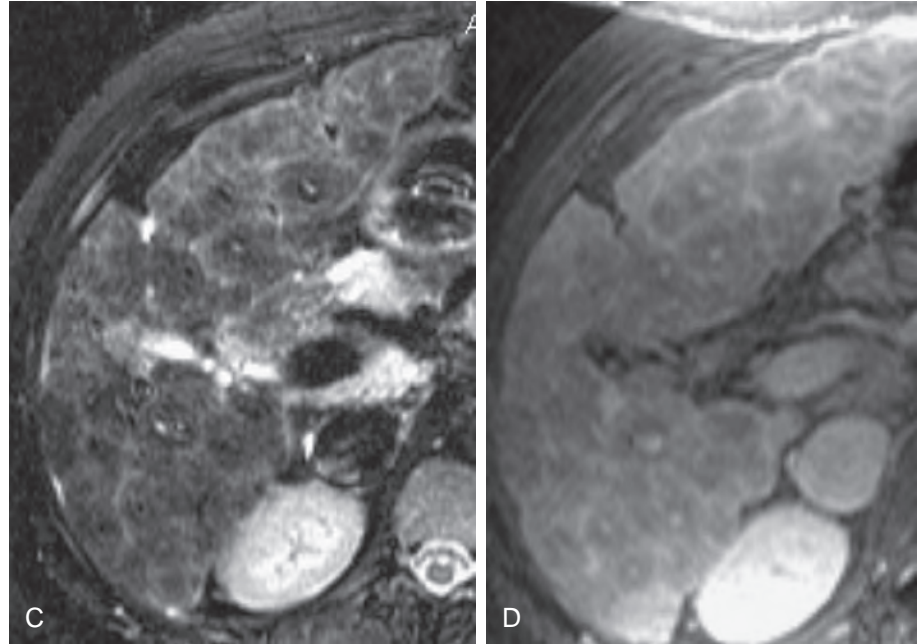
PBC: MR features. A to D. Patients with PBC may have a distinctive, conspicuous abnormality of low signal intensity centered around portal venous branches on T1- and T2-weighted MR images, the “periportal halo sign.” This abnormality consists of a rounded lesion centered on a portal venous branch, 5 mm to 1 cm in size. This pattern may involve all hepatic segments and appear as foci of low signal intensity on T1- and T2-weighted images with no mass effect. These criteria allow differentiation of this finding from regenerating nodules, which are usually of various sizes and signal intensity, may exert mass effect, and are not centered on portal venous branches. (Case courtesy Glenn Krinsky, MD, New York, NY.)
